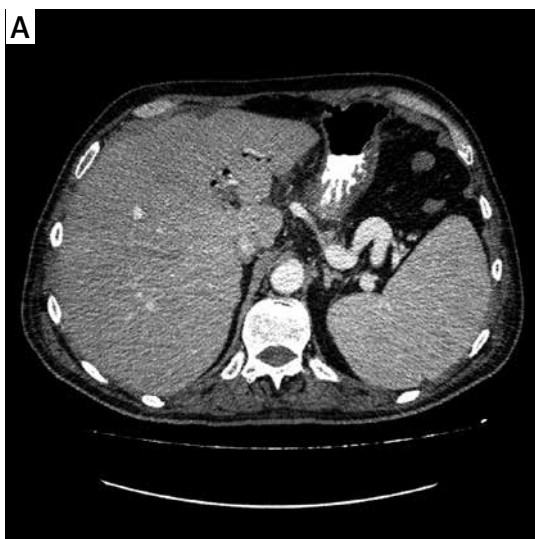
A, B. Closure of the fistula following conservative management, as observed by computed tomography
